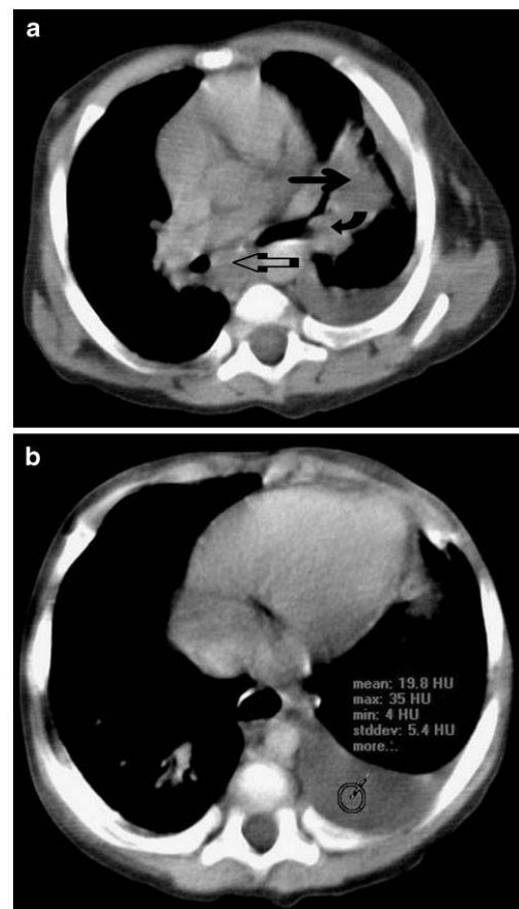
Case 2: CT of the thorax in a 14-month-old boy. a Large subcarinal (*open arrow*) and left hilar (*curved arrow*) tuberculous lymphadenopathy with consequent bronchial narrowing are demonstrated. The patient has a left-sided pleural effusion and air-space opacification involving the lingula (*solid arrow*). b Large left-sided chylothorax with a mean attenuation of 19.8 HU
